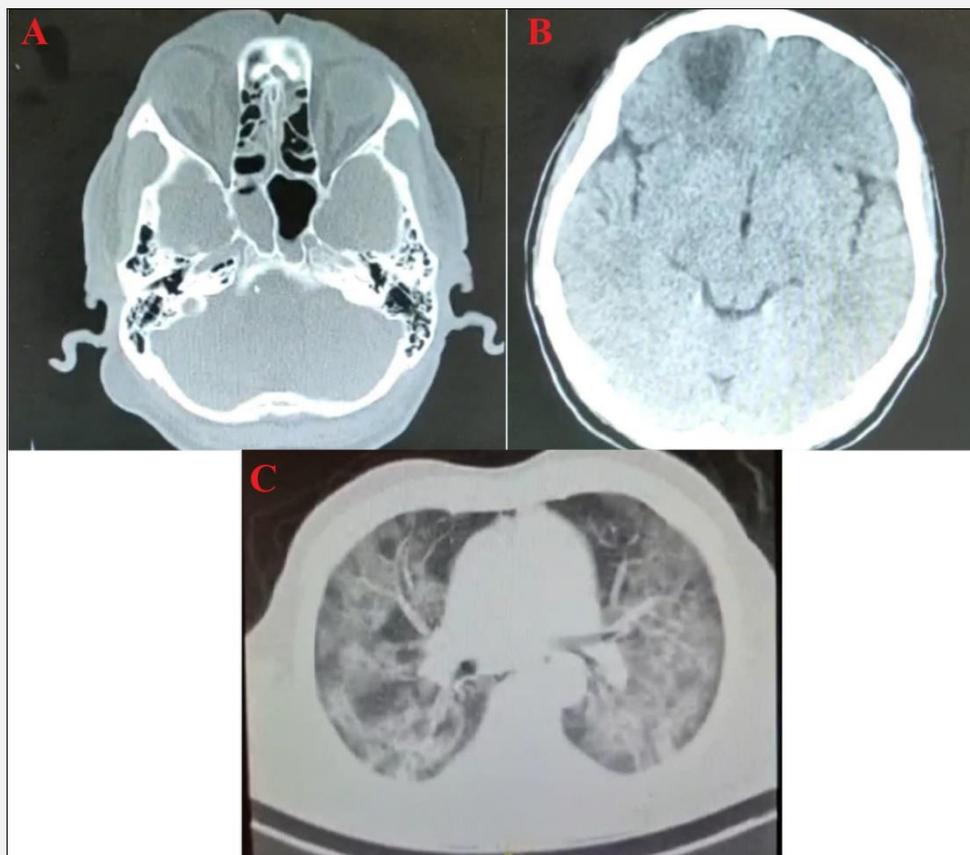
A) PNS CT scan revealed mucosal thickening of all paranasal sinuses, B) Brain CT scan showed hypodense area in antero-inferior cortex and white matter of right frontal lobe, C) CT scan of chest revealed diffuse ground glass opacity.
